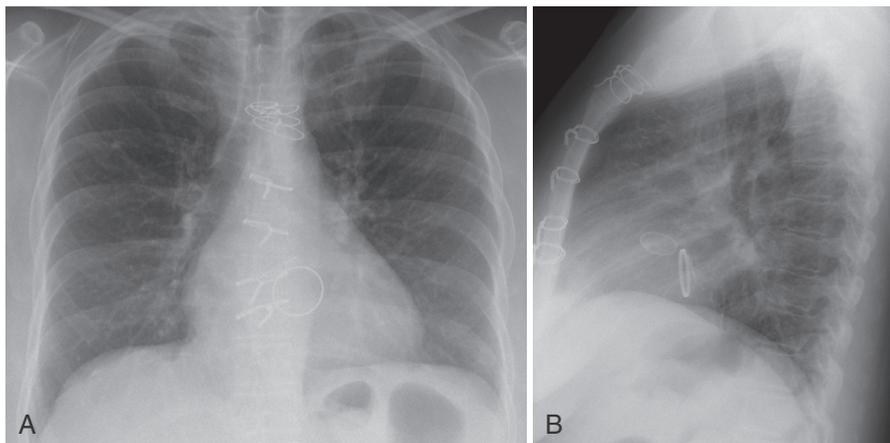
PA and lateral chest x-ray in a patient with bioprosthetic aortic and mitral valves. A, PA view reveals mitral valve ring and linear appearance of aortic valve ring that is in center of heart. The mitral valve is located inferior to the aortic valve. B, Lateral view shows typical magnification of the right hemithorax and right ribs compared with the left hemithorax and left ribs. Mitral valve annulus is posterior to the aortic valve.
